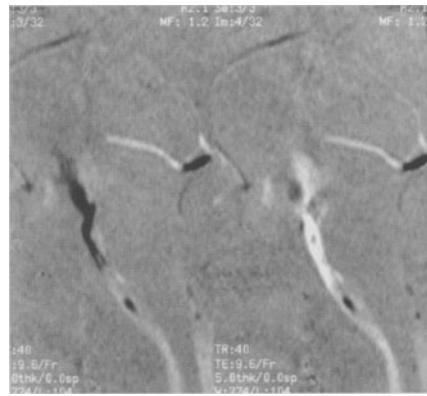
An 11-year-old girl with aqueductal stenosis and ventriculostomy. Sagittal phase contrast cine MRI. Two images are displayed, during systole and diastole. Upward flow is black, downward flow is white. The ventriculostomy is patent, showing alternating black and white flow
